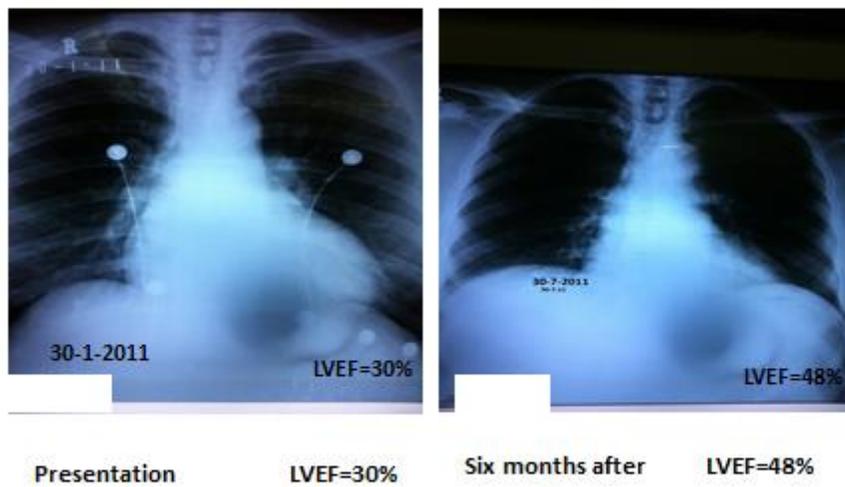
Patient No. 2, chest X-ray showing improvement in cardiac size after arrhythmia control.
